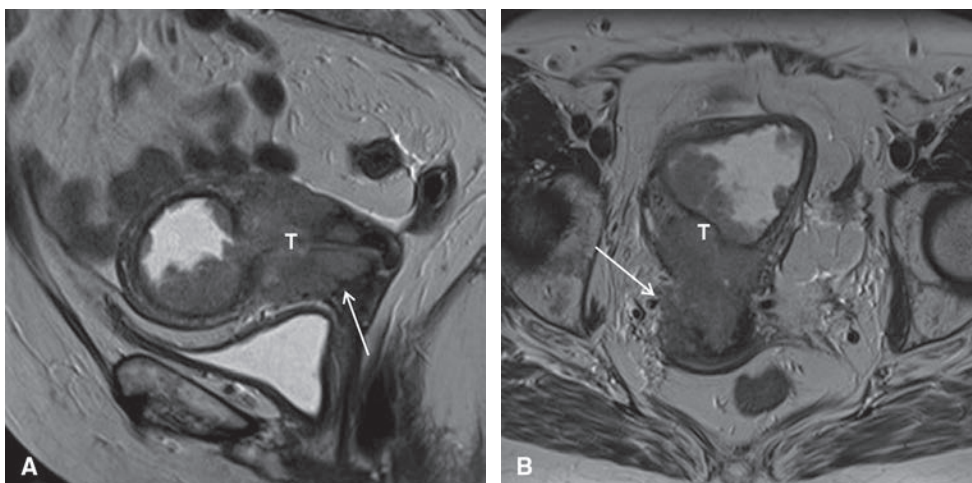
Stage IIIB endometrial carcinoma. Sagittal (A) and axial (B) T2W FSE MR images show an endometrial carcinoma (T in A, B) which invades the cervical stroma (arrow in A) and extends into the right parametrium (arrow in B).
